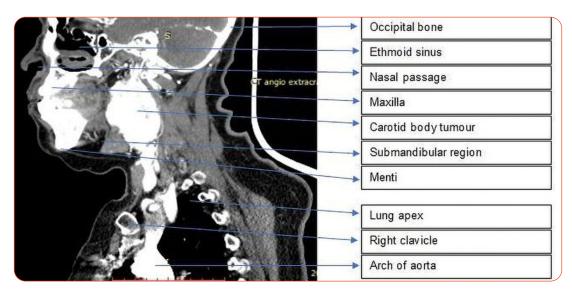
A sagittal, arterial phase CT image demonstrating the extent of the contrast enhanced CBT with labelled anatomy.
